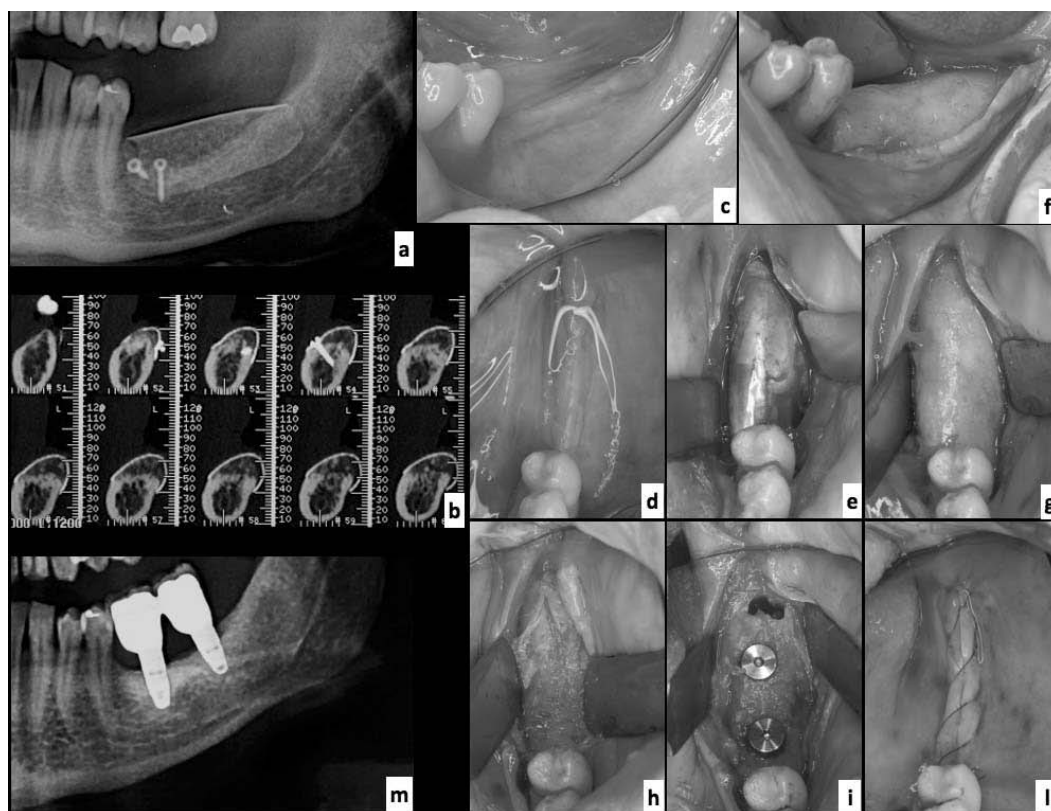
a)* Post-operative panoramic X-ray; *b)* CT-scan of the grafted area was carried out immediately before the second stage surgery; the reached increment was measured vertically and horizontally; *c, d)* intraoral condition at the re-entry; *e)* a full thickness flap is reflected and the device exposed; *f, g)* after device removal, the underlining regenerated area is exposed; *h)* the white connective tissue, covering the graft, is cut and retracted exposing the underlying bone; *i)* after the implant tunnel preparation, two implants are placed; *l)* the flap is sutured; *m)* panoramic X-ray at one-year follow-up, after prosthetic finalization.
